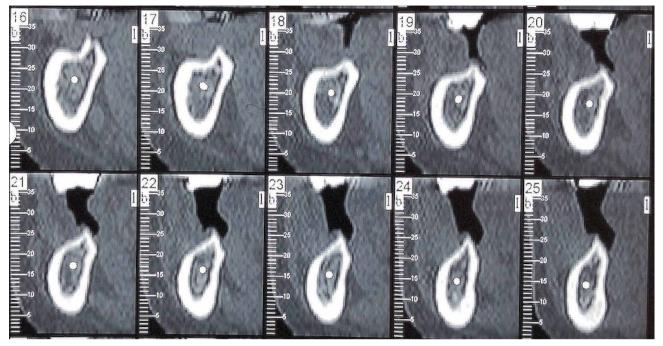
CBCT prior to surgery.
